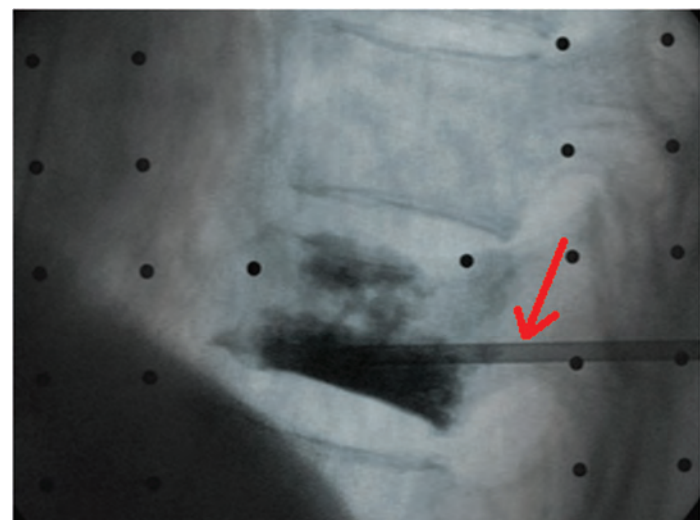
X-ray taken during vertebroplasty with robot-guidance. The compressed bone has been accessed by a needle (red arrow) and filled with synthetic bone cement for stabilization.
